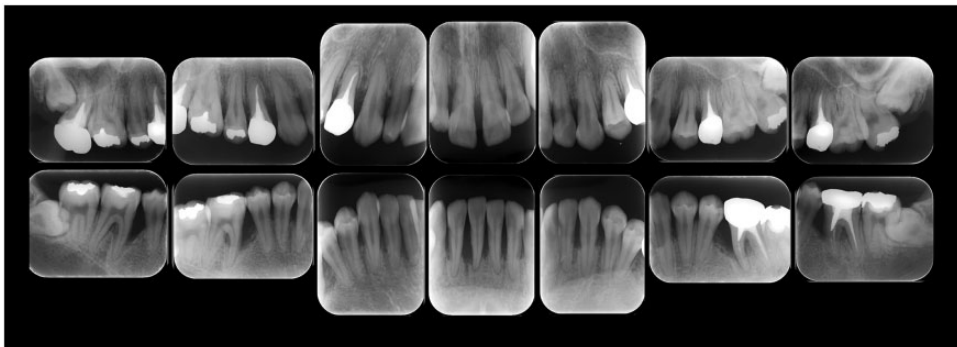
Baseline periapical radiographs (October 2017).
